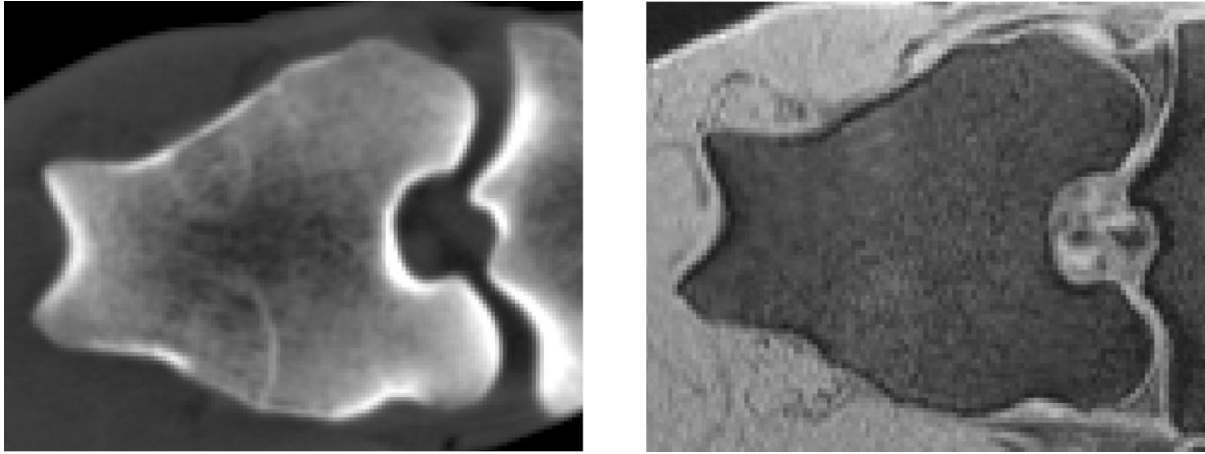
CT (left) and MRI (right) axial slices (the proximal end of the tibia is also visible on the right side of the images as the limb has been scanned with flexed knee joint) from the distal region of the femur. Cortical bone does not generate an MRI signal and appears in black while this is clearly visible in the CT image. Parts of the trabecular structure are visible due to the presence of bone marrow.
